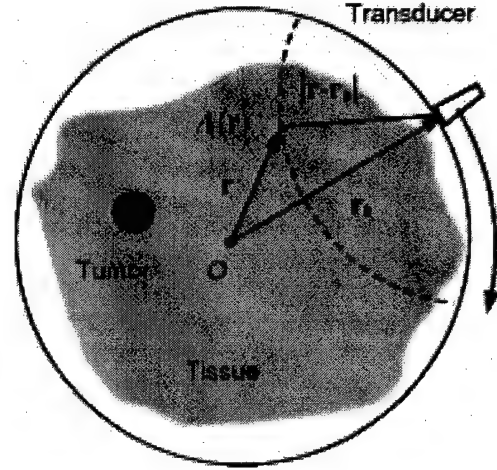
Acoustic detection scheme. The ultrasonic transducer at position \mathbf{r}_0 records the thermoacoustic signals on a spherical surface with radius $|\mathbf{r} - \mathbf{r}_0|$.
